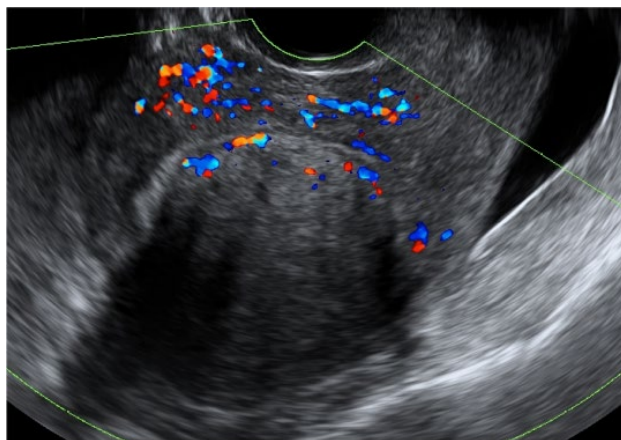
Endometrial polyp with 'pedicle artery' sign on colour Doppler imaging. (See also colour plate 36.4)
